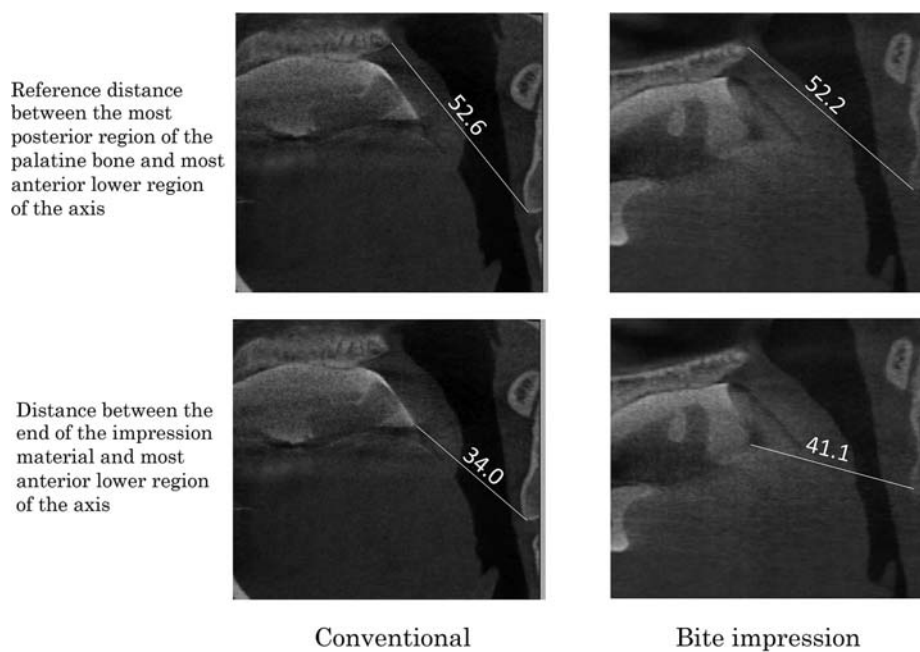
shows an example of a CT image acquired under the measurement conditions. No flow of the impression material was noted into the oropharynx during impression taking in any of the images of the upper, middle, or lower region of the oropharynx in this subject. As well, no flow into the oropharynx occurred in any of the other subjects.
